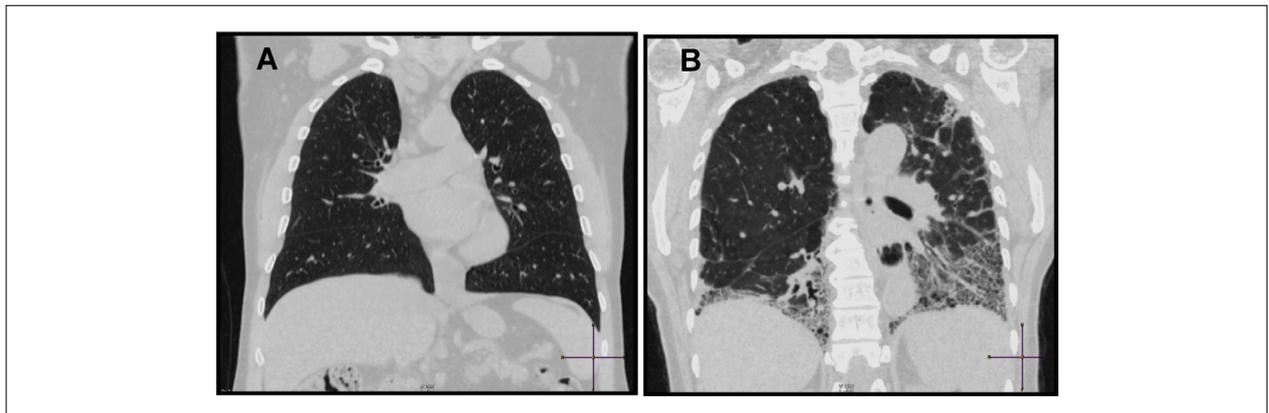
High-resolution chest computed tomography images of patients with systemic sclerosis showing (A) coronal reconstruction of a normal lung parenchyma; and (B) coronal reconstruction of fibrotic interstitial lung disease associated with systemic sclerosis showing reticular opacities, traction bronchiectasis, and honeycombing.
